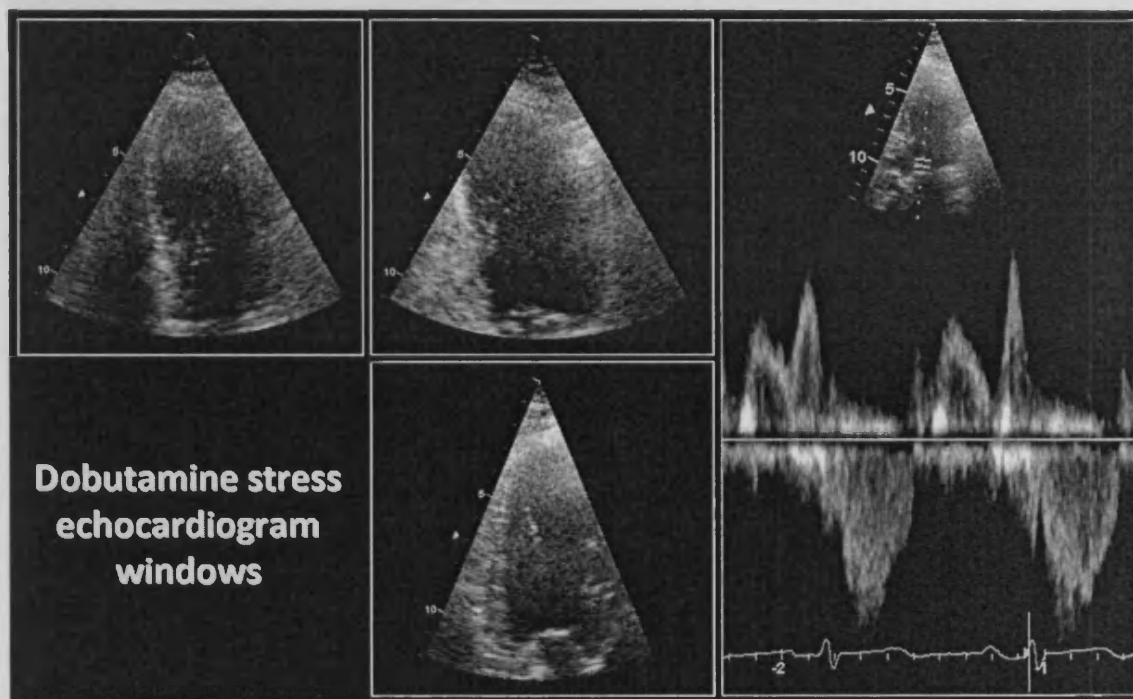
Example images taken at each stage of the DSE protocol. Clockwise from top left: 1. Apical 4 chamber window. 2. Apical 2 chamber window. 3. PWD trace taken at the junction between mitral inflow and aortic outflow. 4: Apical long axis window.
